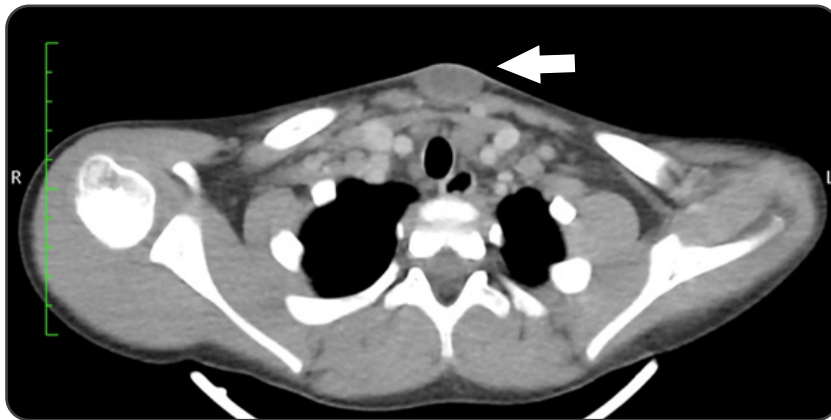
Axial CT scan of the neck and chest at the level of the lesion's largest diameter, indicated by the arrow. Note: The image shows the CT scan of the lesion.
